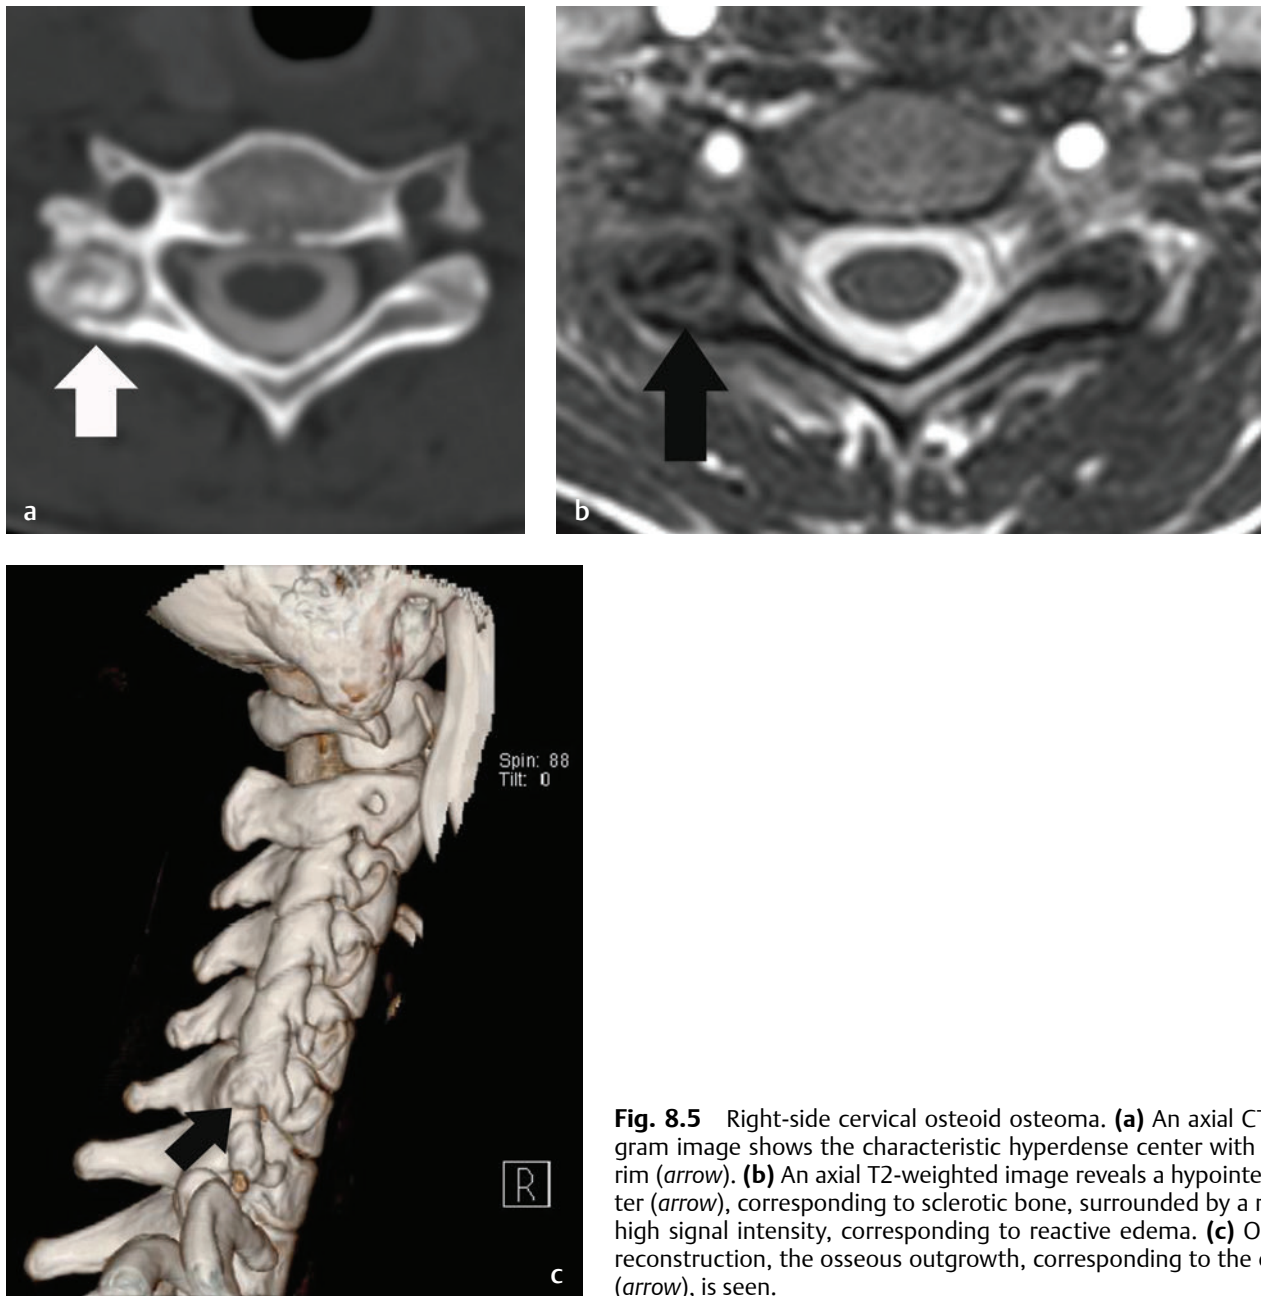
Right-side cervical osteoid osteoma. (a) An axial CT myelogram image shows the characteristic hyperdense center with sclerotic rim (arrow). (b) An axial T2-weighted image reveals a hypointense center (arrow), corresponding to sclerotic bone, surrounded by a region of high signal intensity, corresponding to reactive edema. (c) On 3D CT reconstruction, the osseous outgrowth, corresponding to the osteoma (arrow), is seen.
